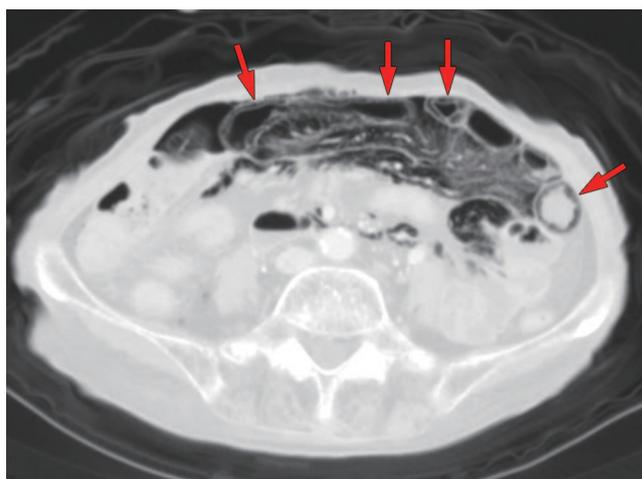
Computed tomography at first onset of pneumatosis cystoides intestinalis demonstrating pneumatosis extending from the duodenum to the ascending colon.
